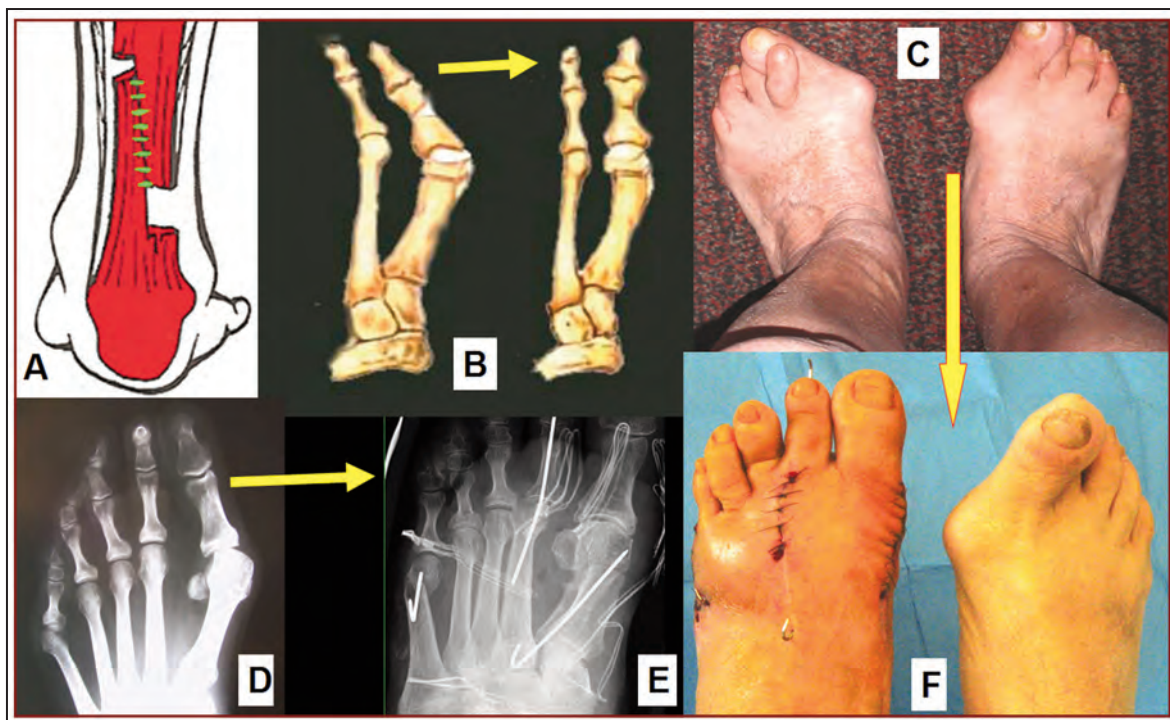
A) Tenotomy of the Achilles tendon with Z-lengthening; B) Corrective osteotomies closing the metatarsal fan; C) Case 2: 60-year-old pensioner with bilateral triangular forefoot; D) X-ray left foot (pre-operative); E) post-operative osteotomy at the neck of I and metacarpal V; F) in the immediate post-operative period the good correction (compared with the counter-lateral foot).
